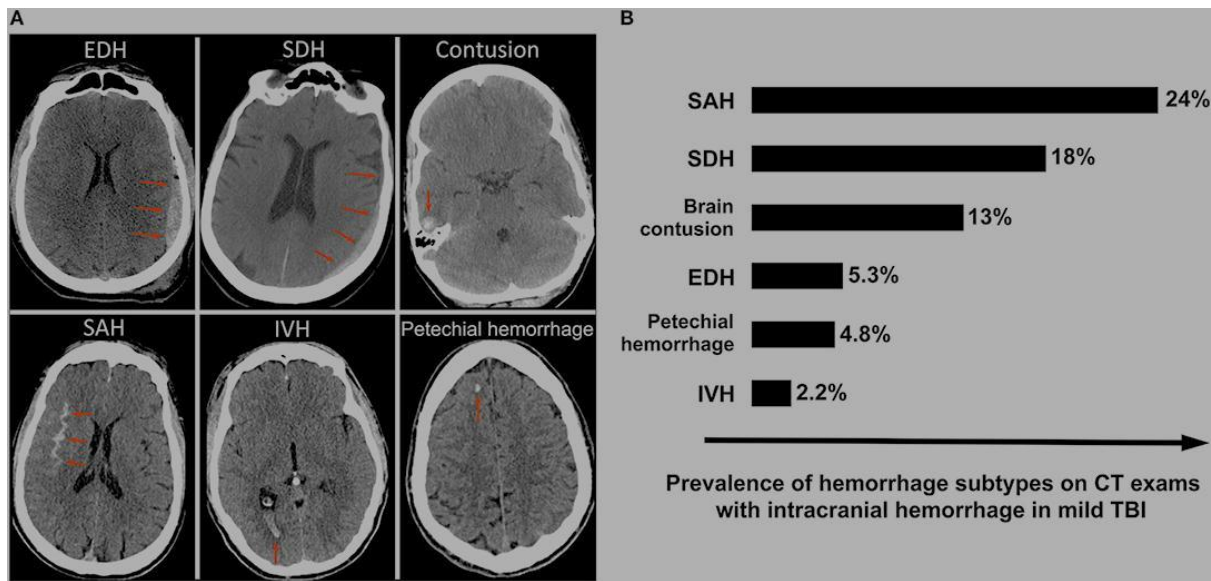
Hemorrhage on CT Examination in mild TBI
